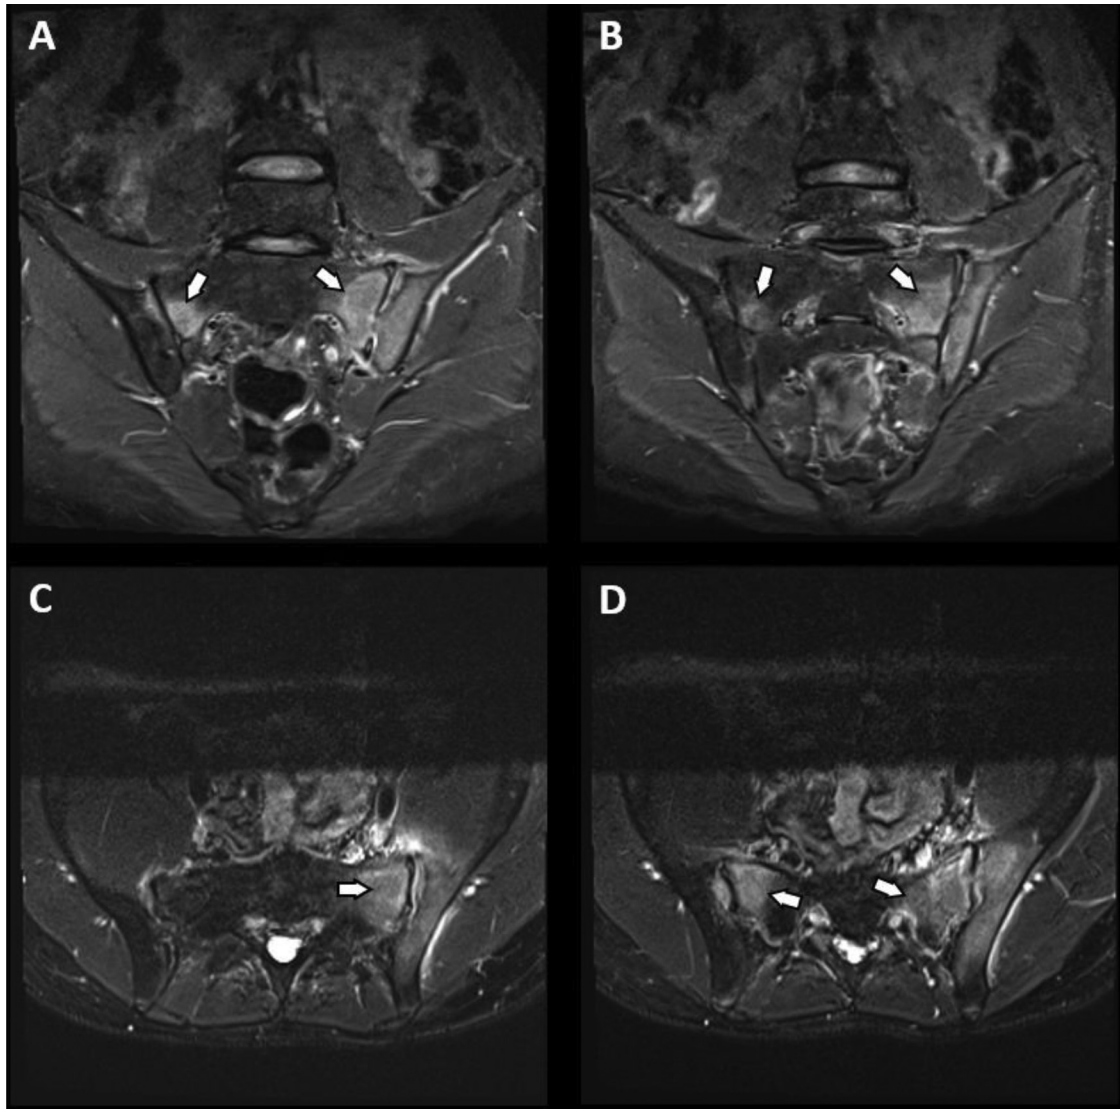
A, B - Coronal STIR sacroiliac MRI. C, D Axial T2 fat saturated sacroiliac joint MRI. Asymmetric osteitis with bilateral bone marrow oedema, more intense at the left sacroiliac joint. MRI, magnetic resonance imaging; STIR, short time inversion recovery.
